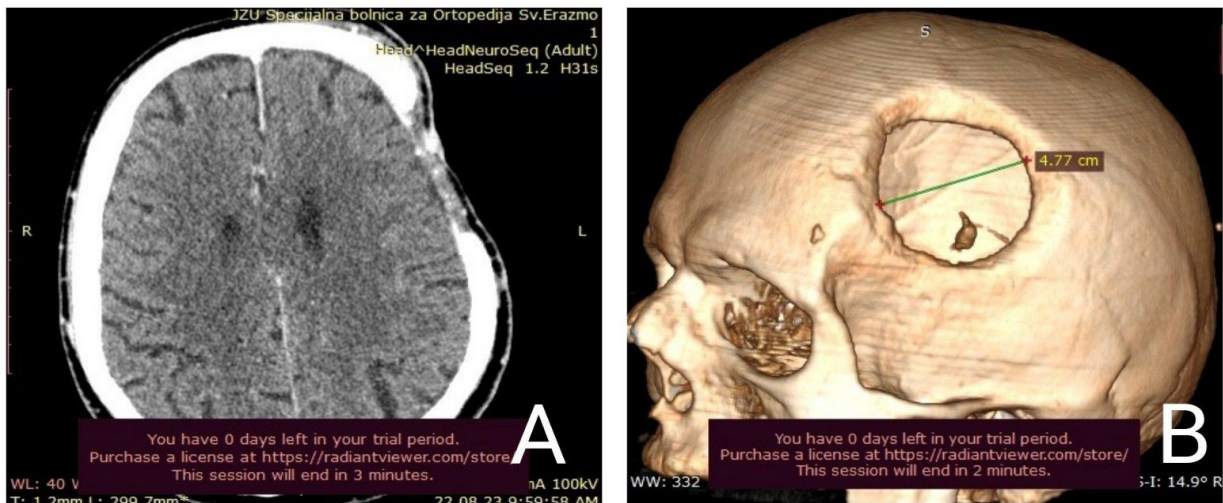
CT result of head and brain postoperatively shows the removal of infiltrated tissue, a narrow subdural hygroma, and a slight subdural hemorrhage in the operated region. Figure 4B. 3D CT result of head and neck postoperatively shows the removal of infiltrated bone tissue, with a width of 4.77cm.
